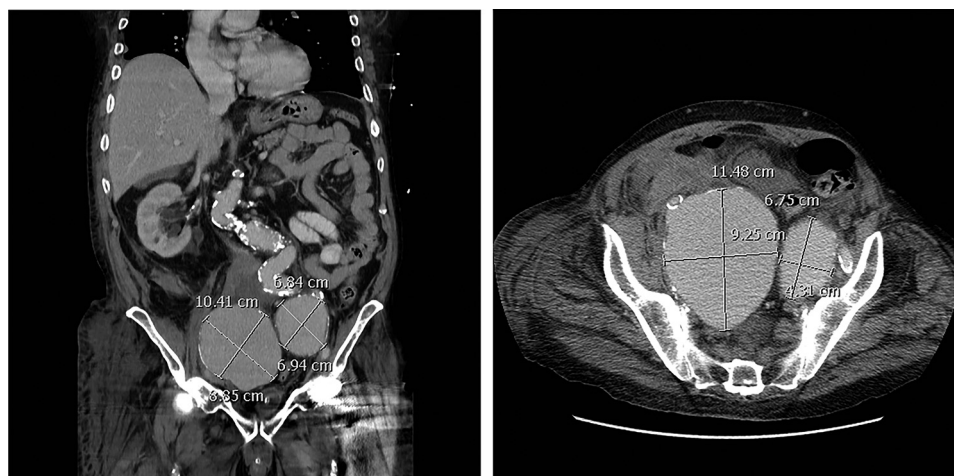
Computed tomography (CT) images of a patient show large internal iliac artery (IIA) aneurysms (IIAAs) on both sides, with rupture on the right side. Diameter measurements are shown for (left) axial and (right) coronal planes.
